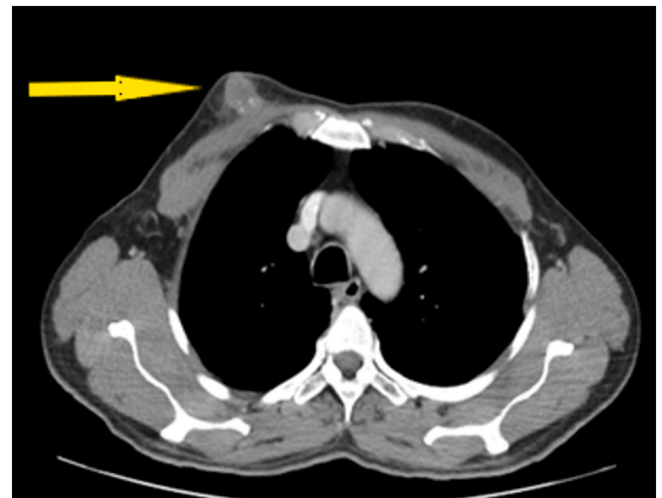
Chest computerized tomography (CT) scan.
